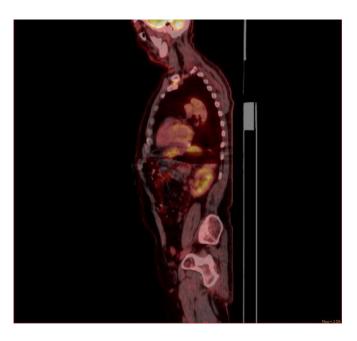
Fusion sagittal reformatted images of a PET-CT Scan show nodular radiotracer uptake in the region corresponding to the left costoclavicular ligament.
